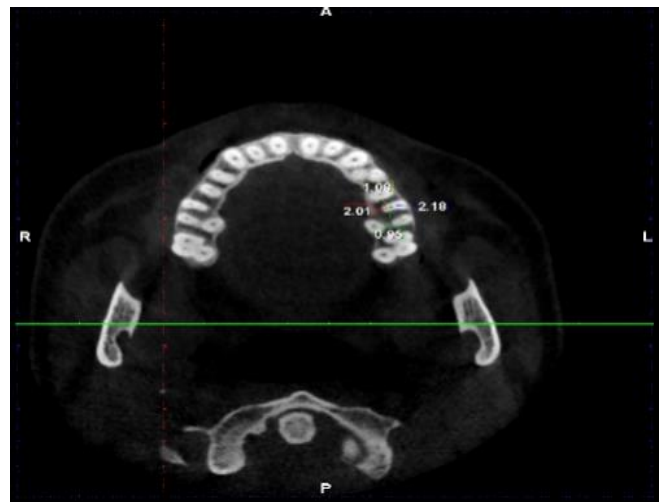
A sample measurement on the CBCT image in apical one-third.
